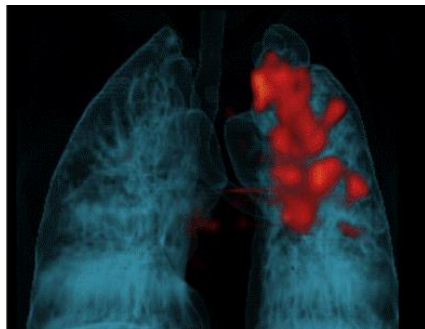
TB-infected lung PET/CT image used for diagnosis, monitoring, and prediction of treatment outcomes. Image credit: NIAID.
